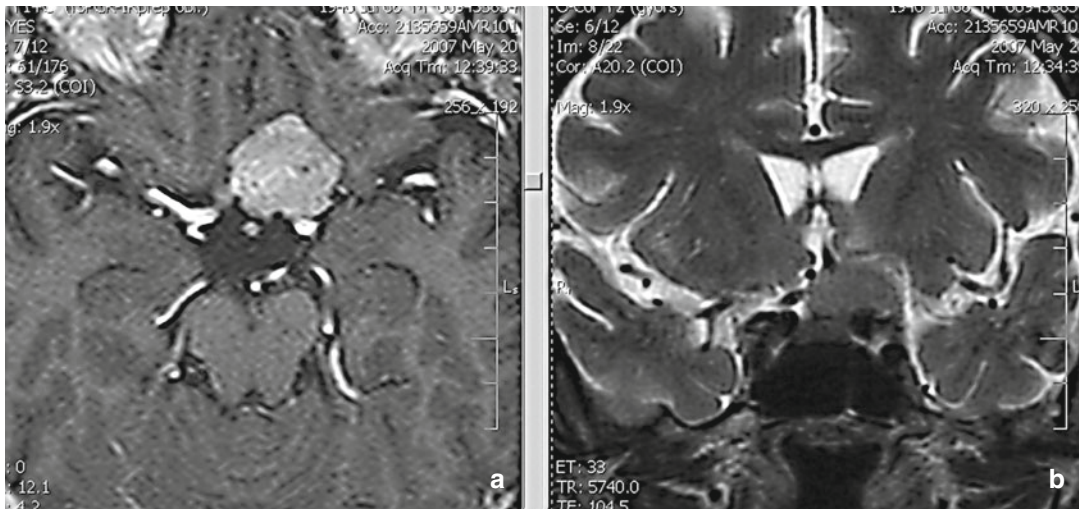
(a) On the left side, an axial, contrast-enhanced, T1-weighted MR scan of an optic foramen-tuberculum sellae meningioma. (b) T2-weighted coronal
